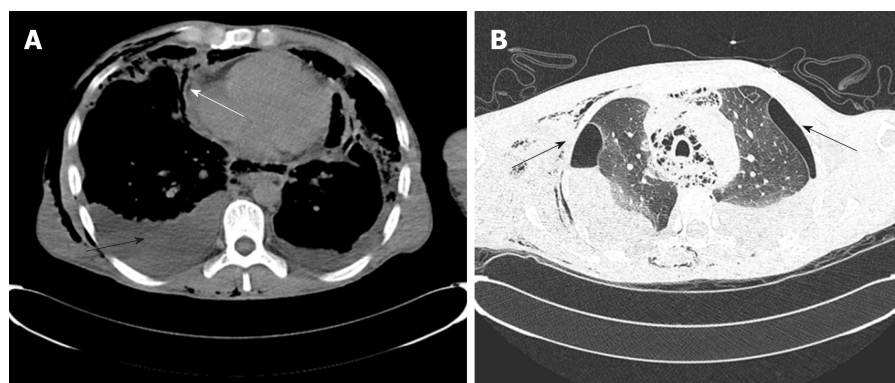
Transverse computed tomography scan of the cardiothoracic region. A: Bilateral pleural effusion (black arrow), pericardial effusion (white arrow); B: Bilateral pneumothorax and pulmonary infection.
